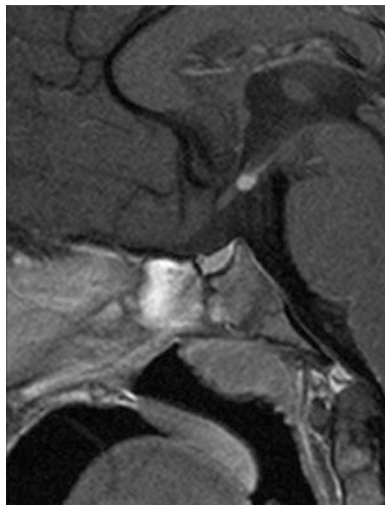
Hypoplastic anterior pituitary with ectopic posterior pituitary in a girl with congenital CPHD (MRI scan from the authors' collections)
